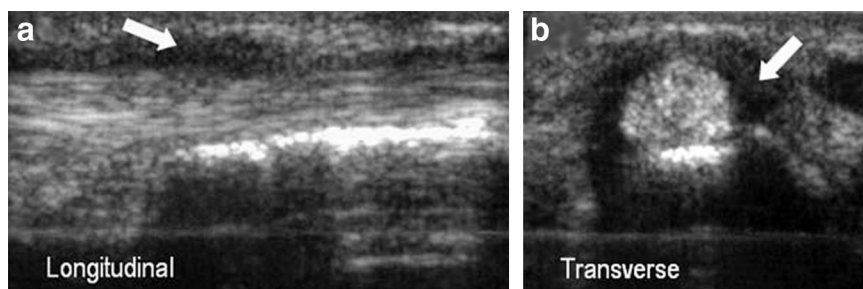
De Quervain tenosynovitis. a, Longitudinal sonogram depicting hypoechoic fluid swelling within the tendon sheath (arrow) of the abductor pollicis longus and extensor pollicis brevis. b, Transverse sonogram showing a hypoechoic ring (arrow) around the tendon, producing the appearance of a target sign.
